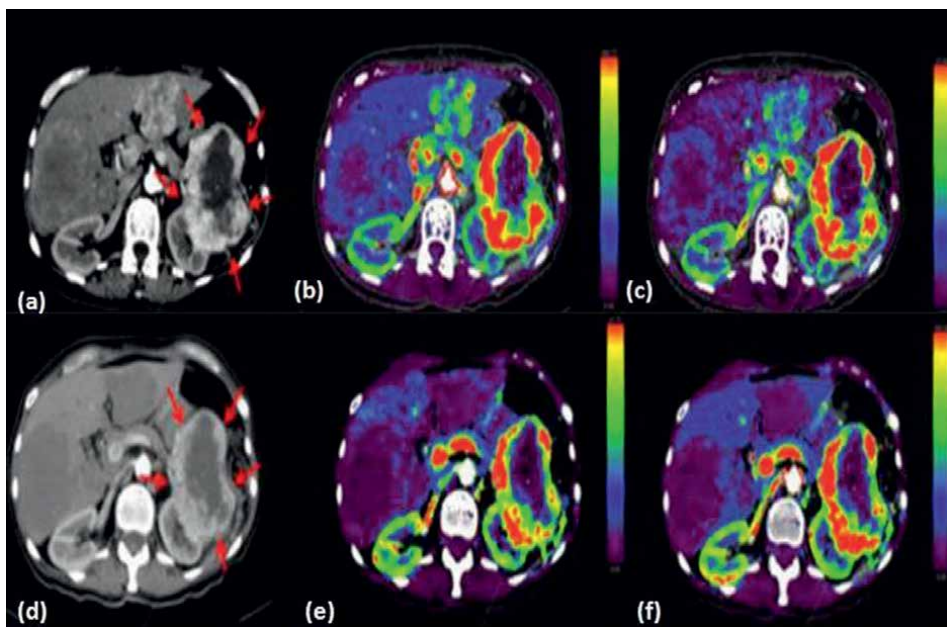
(a-f) Axial images of contrast enhanced CT scan and perfusion of left renal mass. (a-c): Images of left renal mass before starting treatment (red arrows). Blood flow was $116 (\pm 84.12)$ ml/100 ml/min and blood volume is $13.79 (\pm 7.79)$ ml/100 ml. (d-f) Similar patient at 8 days of starting treatment. The blood flow showed mild reduction to $100.13 (\pm 77.96)$ ml/100 ml/min and blood volume to $10.38 (\pm 9.6)$ ml/100 ml [17].
